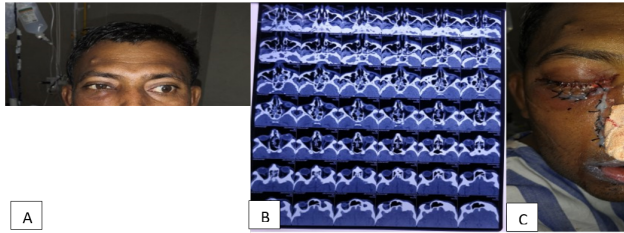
A): Photograph of patient with right eye periorbital edema and chemosis; B): Axial magnetic resonance imaging T1-weighted scan showing signs of right maxillary, frontal, ethmoid and sphenoid sinusitis with the involvement of right inferior rectus muscle and extraconal fat; C): Post-operative picture of the patient who underwent right total maxillectomy, ethmoidectomy, uncinctomy, sphenoidectomy, debridement of inferior rectus muscle and removal of right orbital floor
